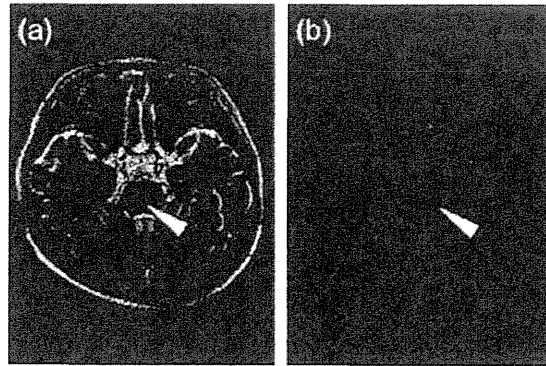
(a) T2-weighted images showing hyperintensity in the middle cerebellar peduncle to the pons (arrowhead). (b) DWI sequence clearly showing an increased signal in the pons (arrowhead).
